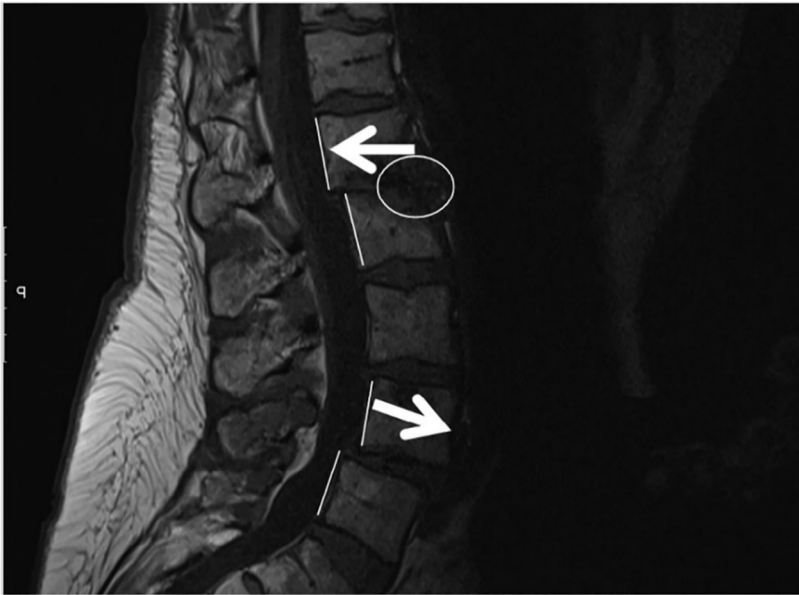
An MRI scan of a degenerative lumbar spine, showing at L1 to L2 both disc collapse (oval) as a result of the axial force and retrolisthesis (posterior arrow) as a result of the posterior force, and at L4 to L5 anterolisthesis (anterior arrow) as a result of the anterior force.
